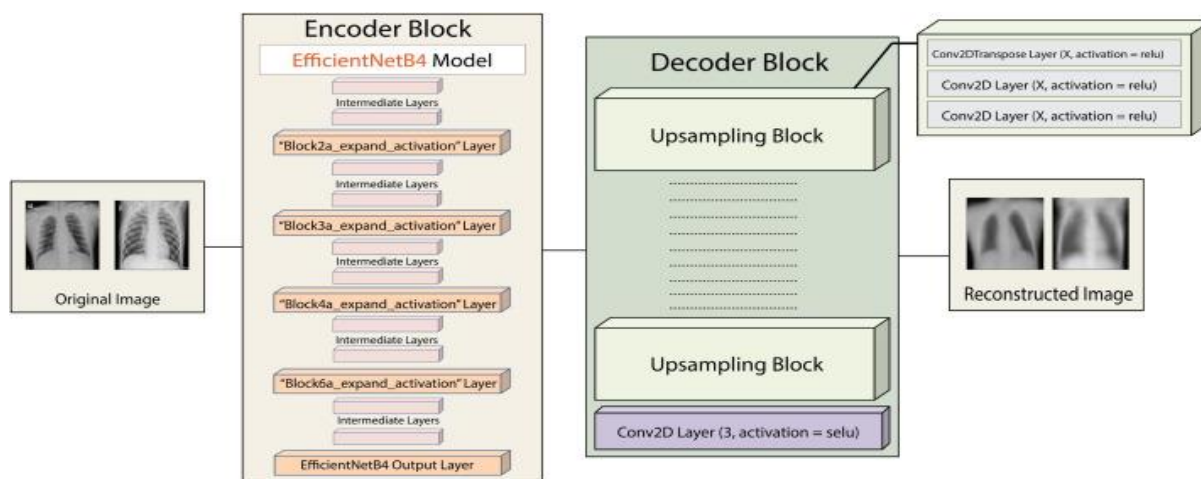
The proposed autoencoder framework consists of two-stage training: (1) training the autoencoder network using the input X-ray images and (2) training the intermediate layers of the encoder network (utilizing weights obtained in the first stage) followed by the merging network. Output from the merging network is passed to a classification network that makes the final classification.
